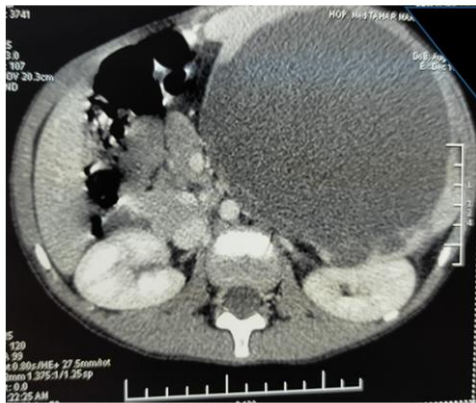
CT: Limited cystic mass at splenic upper pole
